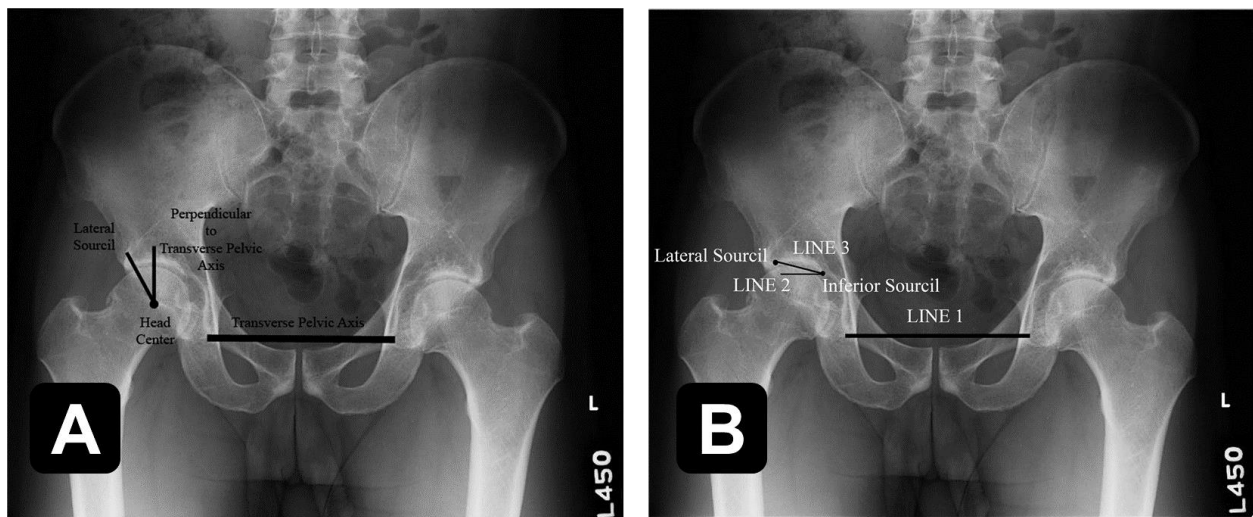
Standard radiographic measures of (A) the lateral center-edge angle (LCEA) to quantify lateral femoral coverage; and the (B) acetabular inclination (AI) or Tönnis angle to quantify orientation of the weight-bearing area of the acetabulum. (Adapted from Figure 11 in Clohisy et al. J Bone Joint Surg Am. 2008 [39].)
